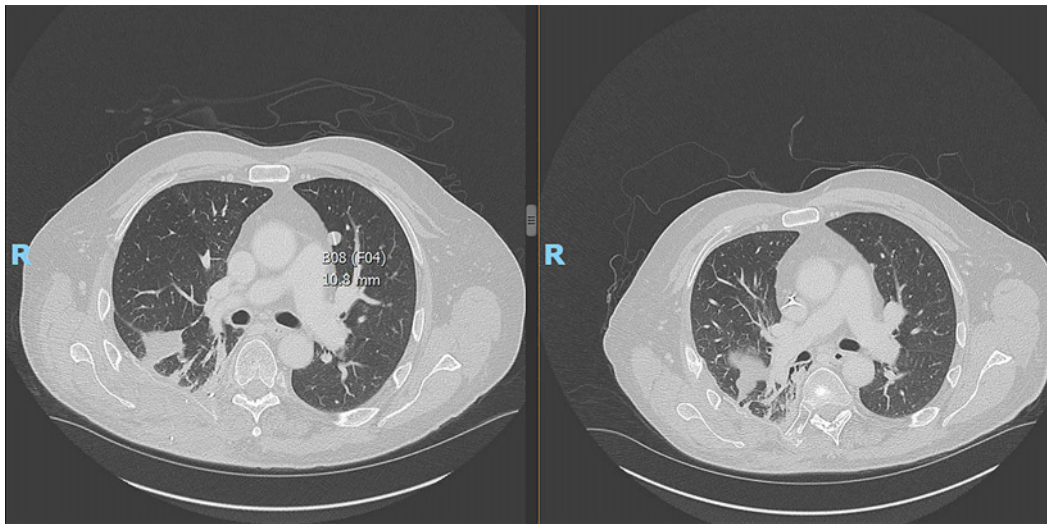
Single transverse section of a CT chest scan demonstrating partial response; the previously visualized nodule underwent significant decrease in size.
